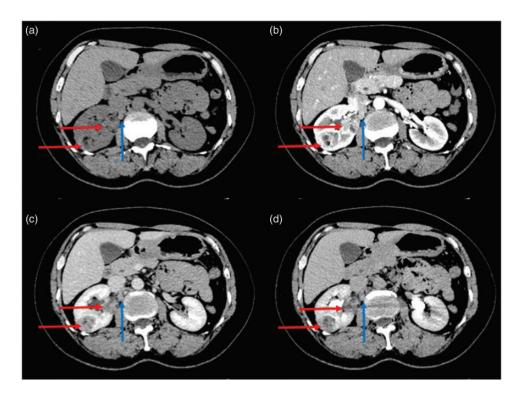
Non-contrast-enhanced computed tomography (a) and contrast-enhanced computed tomography (corticomedullary phase: b, nephrographic phase: c, excretory phase: d). Two heterogeneous enhanced tumors (red arrow) were present in the right kidney. A hilar lymph node was noted (blue arrow).
